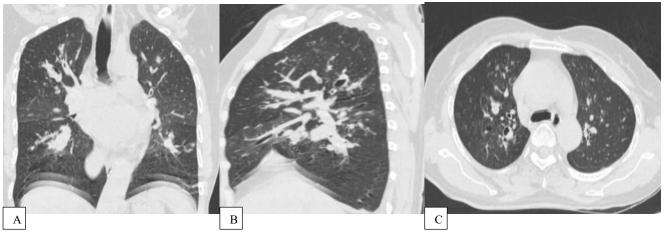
(A-C): HRCT lung images show central cystic and tubular bronchiectasis in bilateral upper and right middle lobes with mucoid impaction, producing a "finger-in-glove" appearance.
